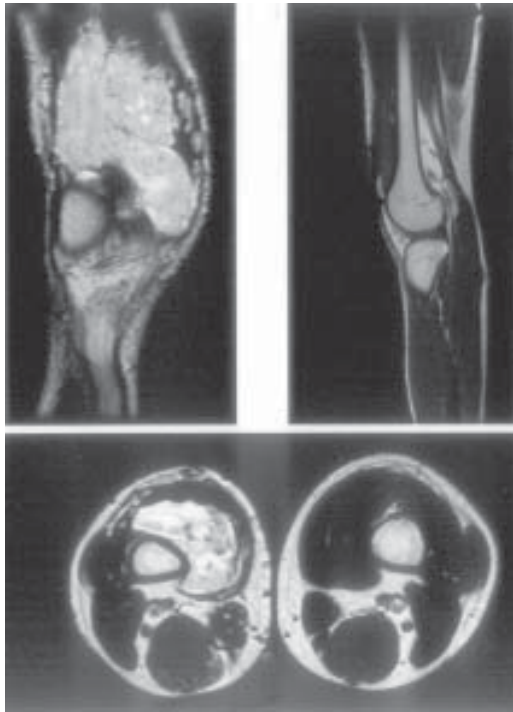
T2 weighted coronal (A) and axial (B) MRI images show the lesion as hyperintense region just anterior and medial to the right lower femur. T1 weighter sagittal image (C) shows the isodense lesion anterior to the femur around the patello-femoral joint.
